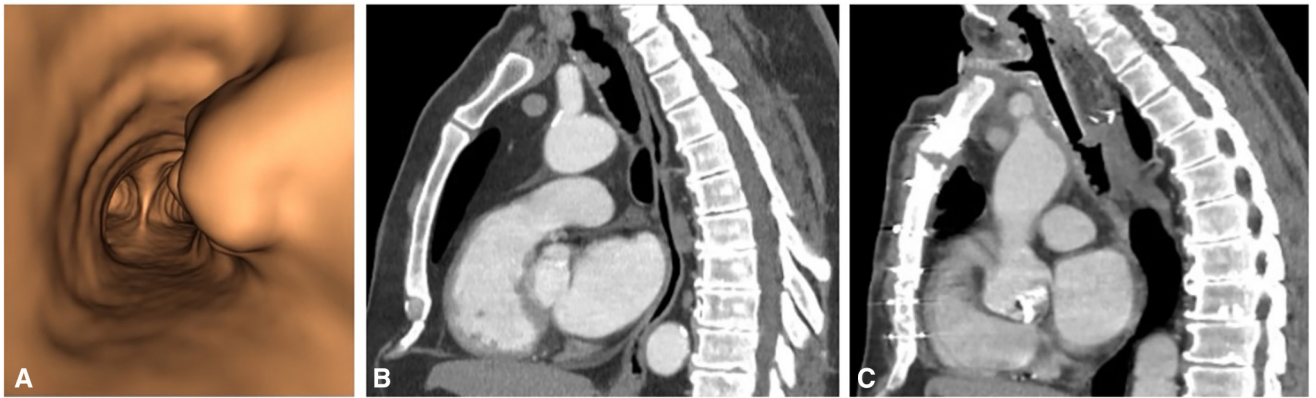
A, Three-dimensional imaging reconstruction of endotracheal tumor. B, Preoperative computed tomography imaging of the chest, sagittal view. Lobulated soft tissue at the anterior part of the proximal trachea at T1–T2 vertebral levels with an additional right lateral nodule at T2–T3. C, Post-operative computed tomography imaging of the chest, sagittal view, at 6 months. T-tube in place.
